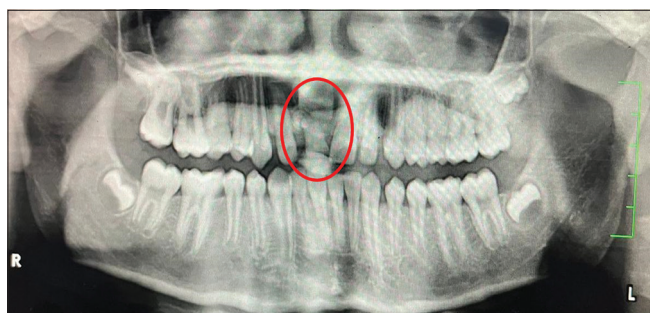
Panoramic radiograph with radiopaque mass of calcified structures
